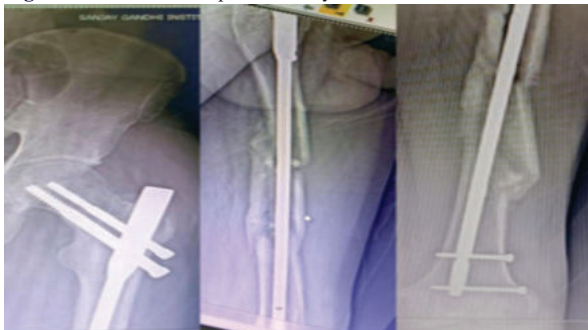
Months Follow Up Xrays
